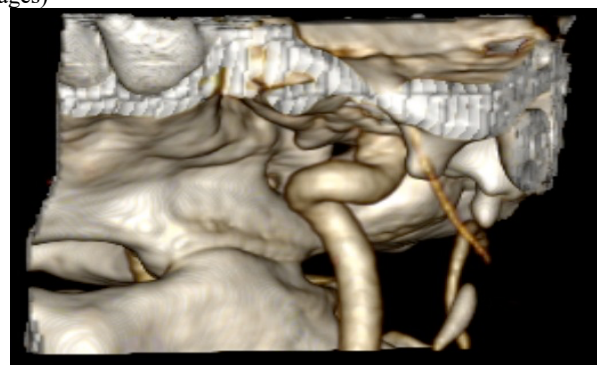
Coiling of the left internal carotid artery cervical segment (3 dimensional reconstruction of computed tomography angiography images)
